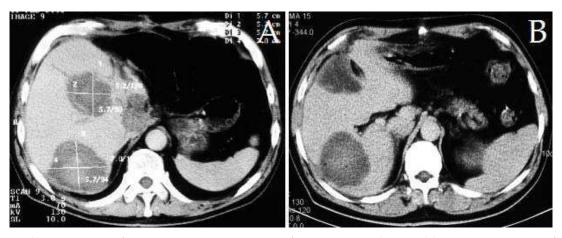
Follow-up CT after intraoperative RFA of recurrent colorectal liver metastases after previous resection (A), and of colorectal metastases in a high-risk patient (B) .
